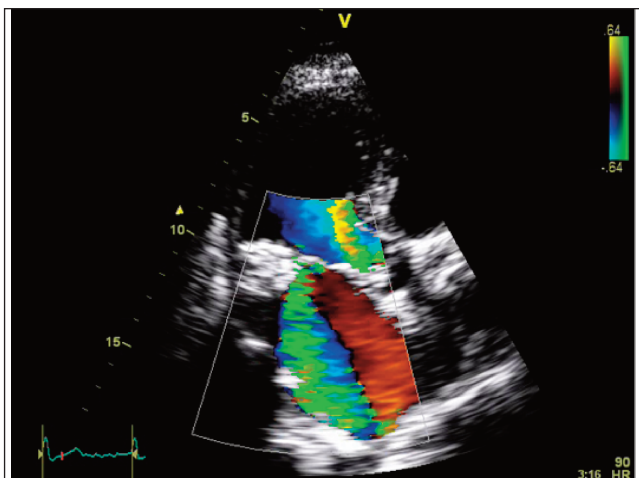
c: Mitral regurgitation jet on colour flow Doppler.
